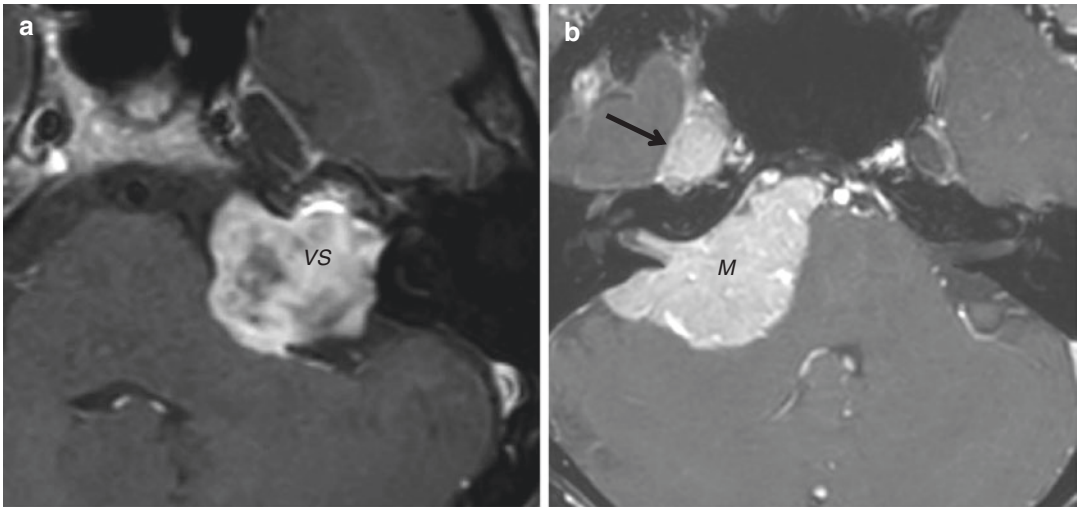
Examples of secondary hemifacial spasm. (a) Vestibular schwannoma. Axial contrast-enhanced T1-weighted MRI shows a large lobulated soft tissue mass (*VS*) with heterogeneous enhancement in the left cerebellopontine angle. The internal auditory canal is replaced and marked widened by the mass. The brain stem is compressed by the mass as well. (b) Meningioma. Axial
